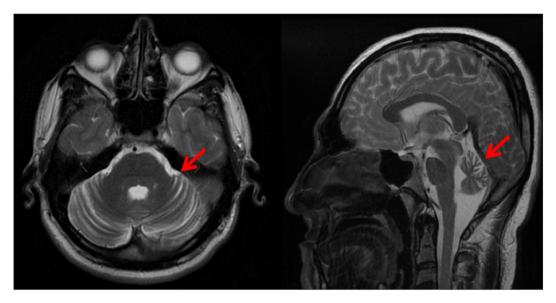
Brain magnetic resonance imaging of case III7. The red arrows reveal marked symmetric cerebellar atrophy. The color version of this figure is available in the online edition.
